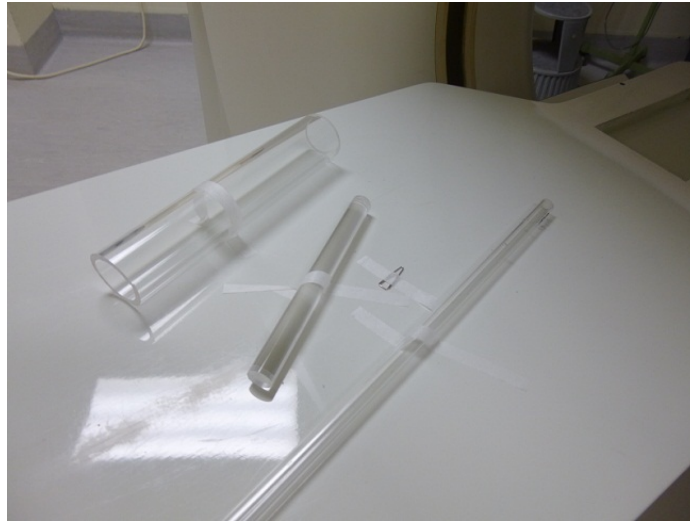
The three acrylic tubes taped to the CT couch ready for scanning. The paper clip is a longitudinal reference point.
